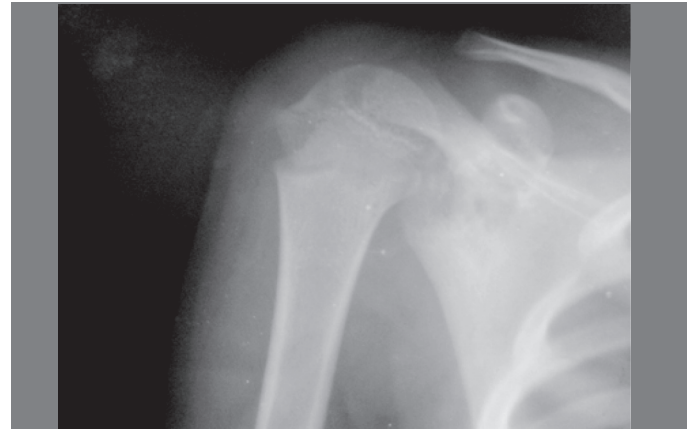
X-ray AP view scapula showing geographical lesion scapular neck.
